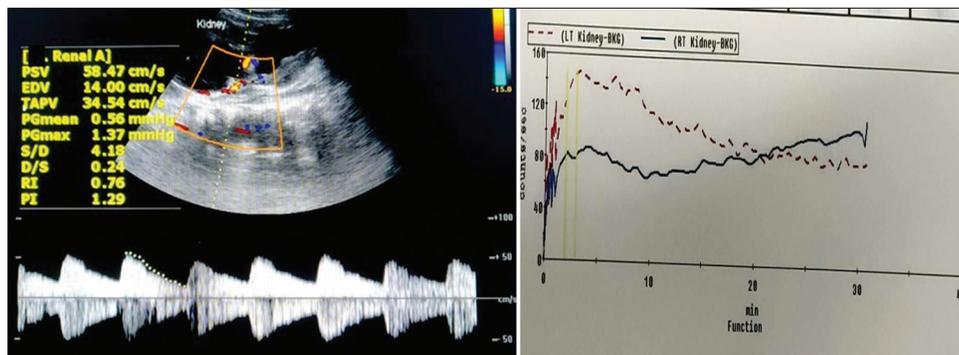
shows Colour Doppler image showing an RI of 0.76 of the renal artery at hilum of the left kidney. DTPA study in this patient showed an obstructive pattern with no significant lasix washout response.Thus this was a true positive case, where the colour Doppler study findings correlated with the DTPA study in a case of obstructive hydronephrosis
